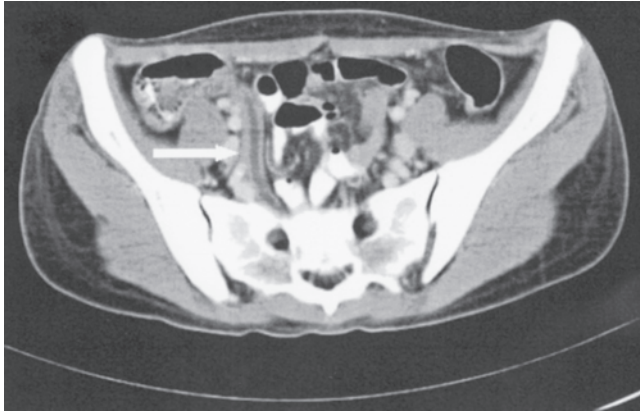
CT of acute appendicitis. The *arrow* points to an enlarged, fluid-filled appendix with wall hyperemia that does not fill with oral contrast. The paucity of intra-abdominal fat limits identification of fat stranding. (Used, with permission, from M. Stephen Ledbetter, MD, MPH, Brigham and Women's Hospital, Boston, MA.)
